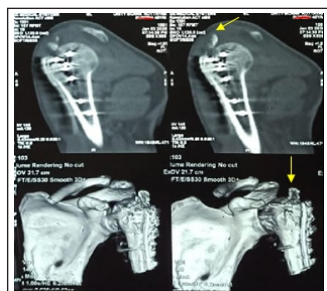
Postoperative CT At 8 Weeks showing displaced GT (arrow)
